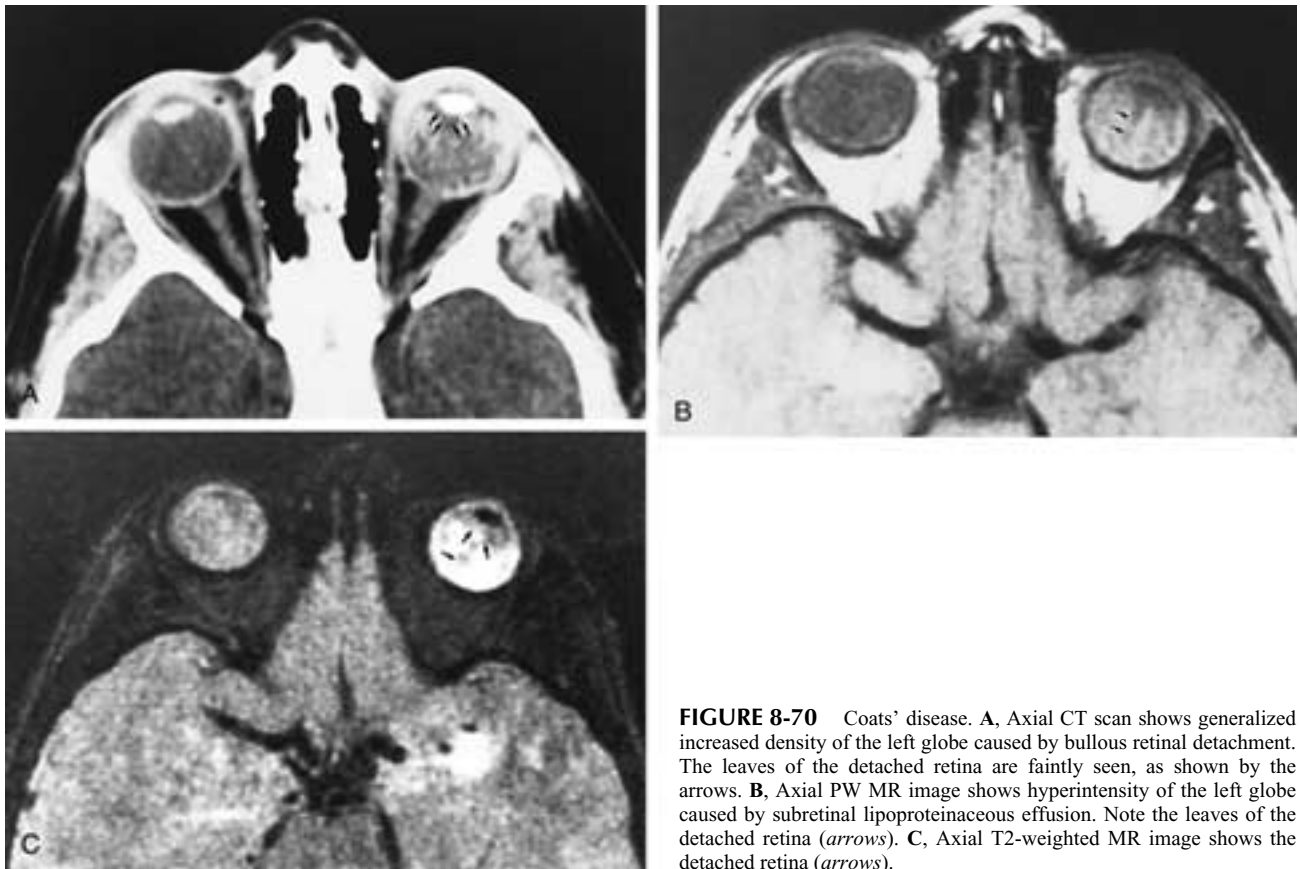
Coats' disease. A, Axial CT scan shows generalized increased density of the left globe caused by bullous retinal detachment. The leaves of the detached retina are faintly seen, as shown by the arrows. B, Axial PW MR image shows hyperintensity of the left globe caused by subretinal lipoproteinaceous effusion. Note the leaves of the detached retina (*arrows*). C, Axial T2-weighted MR image shows the detached retina (*arrows*).
